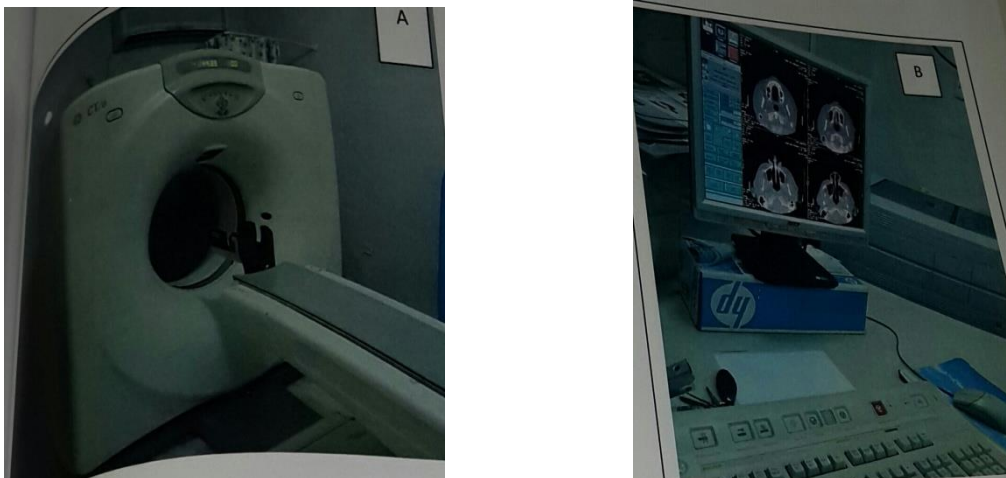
A&B show CT equipment
